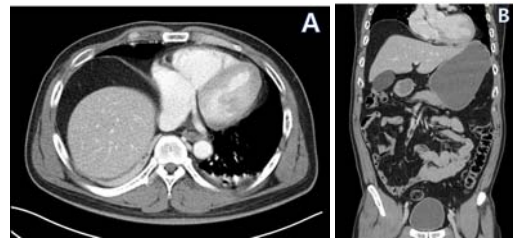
Abdomen computed tomography shows intraperitoneal fat pad localized between the diaphragm and liver. (A) axial view, (B) coronal view.
